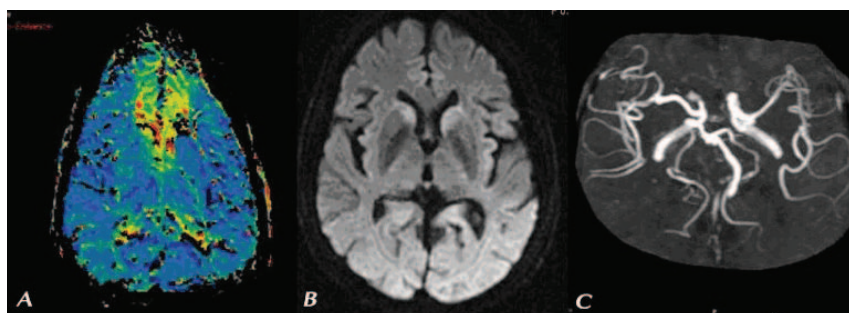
Brain MRI and MRA of the patient after rt-PA injection. (A) Perfusion weighted image showed perfusion defect of the bilateral ACA territories. (B) Diffusion weighted image showed acute infarctions of the bilateral caudate nuclei. (C) Non-visualization of the bilateral ACAs was seen on magnetic resonance angiography.
